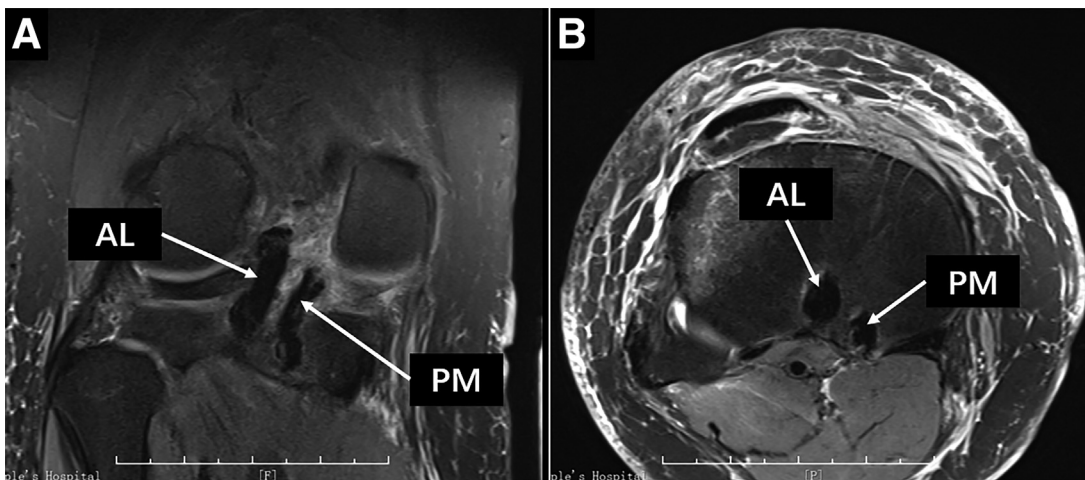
Postoperative coronary (A) and transverse (B) view magnetic resonance images (right knee). AL, the anterolateral-bundle graft; PM, the posteromedial-bundle graft.
